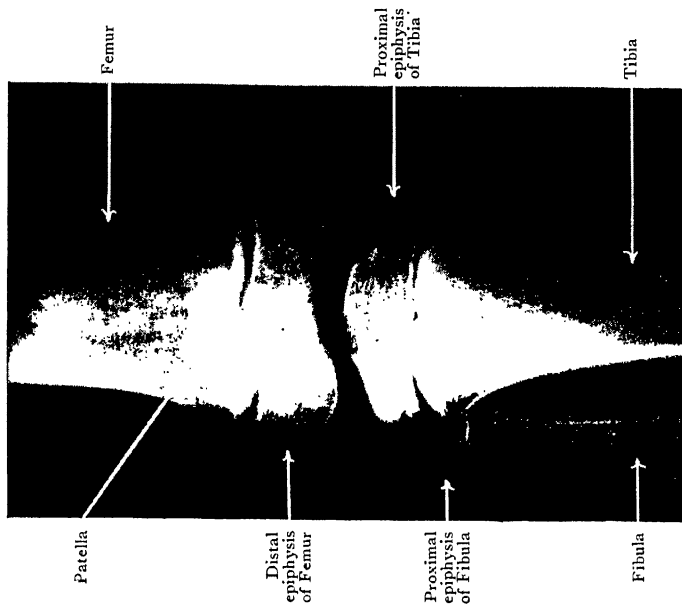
Radiograph of Knee of boy aged 7. Note the size of the patella and its position in comparison with Fig. 179B.
